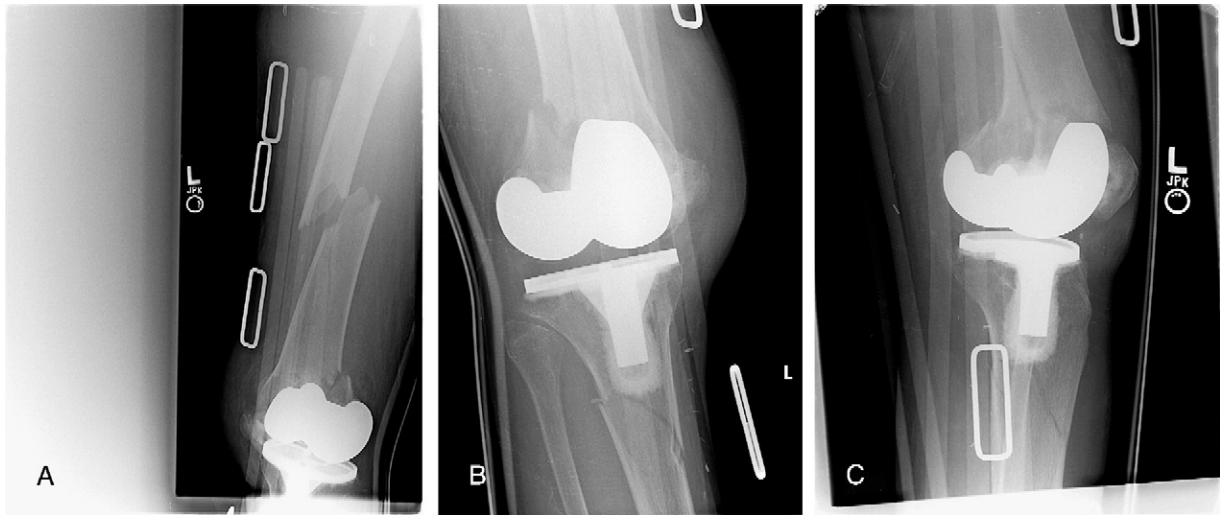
A-C, Preoperative femur (A) and knee (B and C) radiographs obtained after the injury demonstrating periprosthetic femoral shaft/supracondylar fracture with an ipsilateral tibial periprosthetic fracture. This injury is termed a *floating prosthesis injury*.
